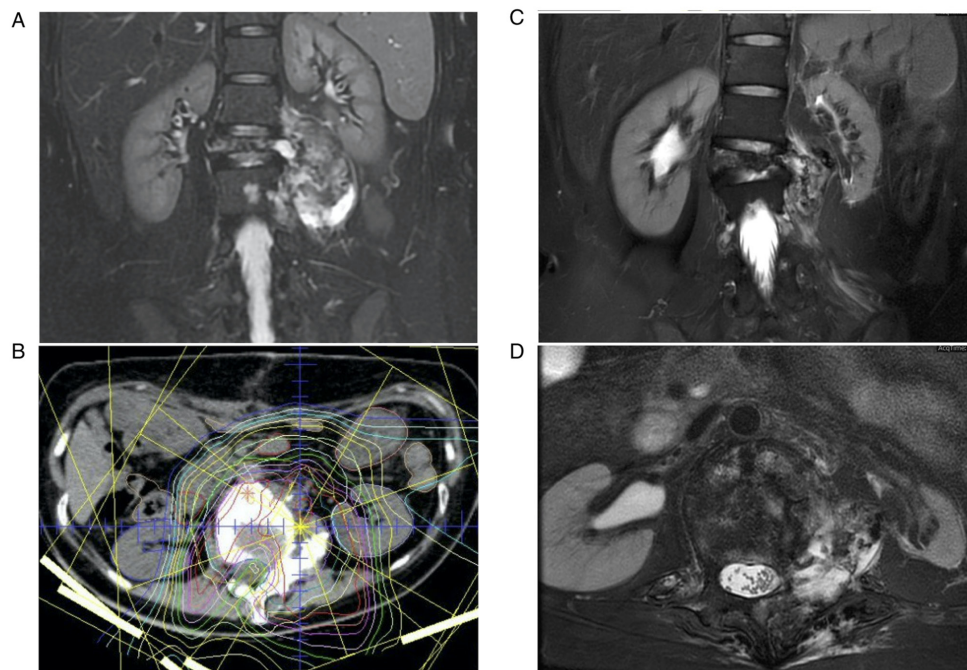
(A) After 4 courses of doxorubicin and ifosfamide, a partial response was seen on MRI. (B) Dose distribution of proton beam therapy. (C and D) MRI at the most recent follow-up 7.8 years after the initial diagnosis shows no evidence of relapse. MRI, magnetic resonance imaging.
